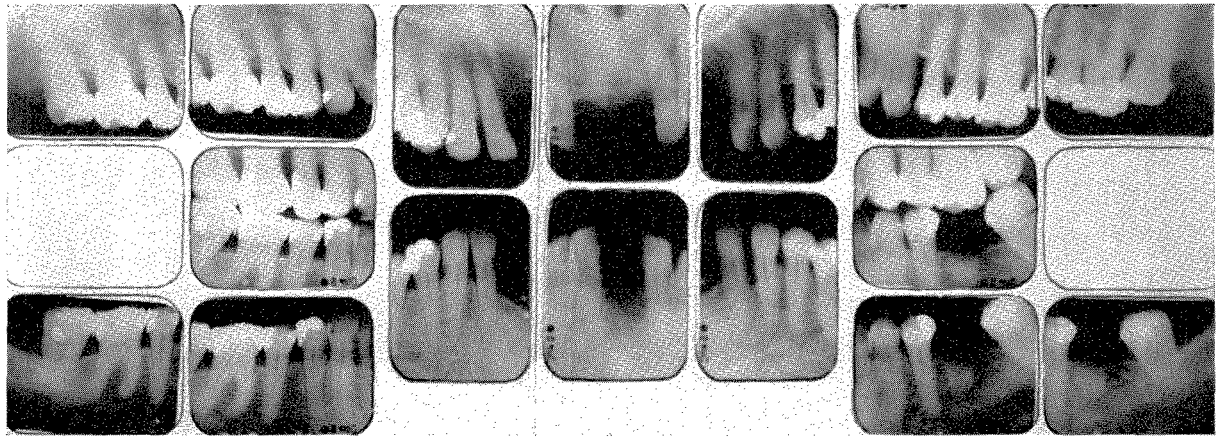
Roentgenograms taken in 1962 at the age of 55.
